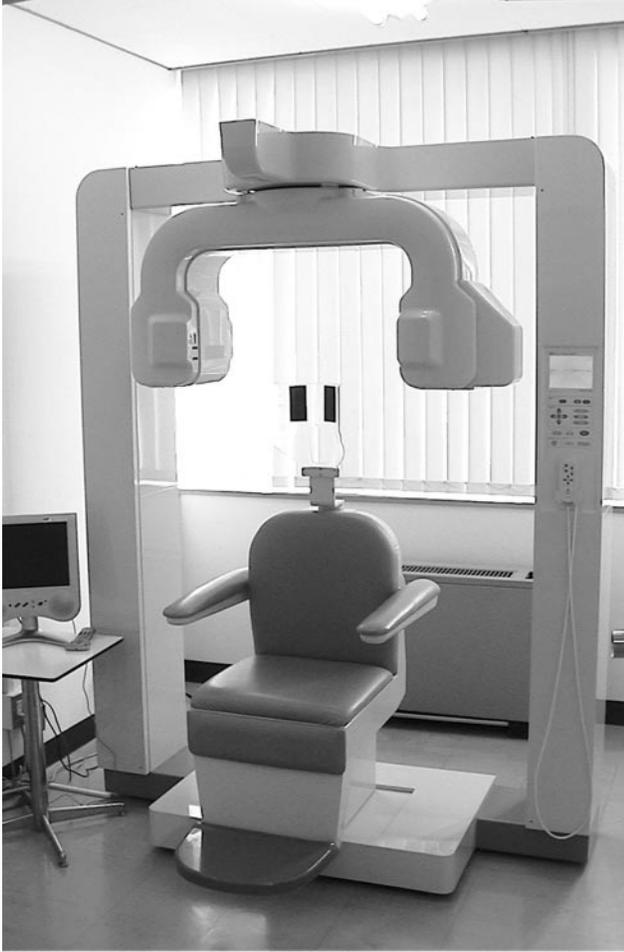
The new limited cone beam–type computed tomography apparatus (The 3DX multi-image micro-computed tomography [CT]).
